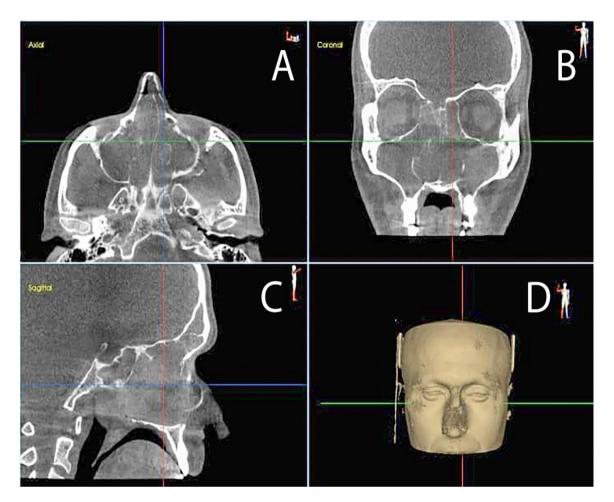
Axial (A), coronal (B), sagittal (C) and 3D re-construction of the images acquired using CBCT of a patient with polyposis and chronic rhinosinusitis
